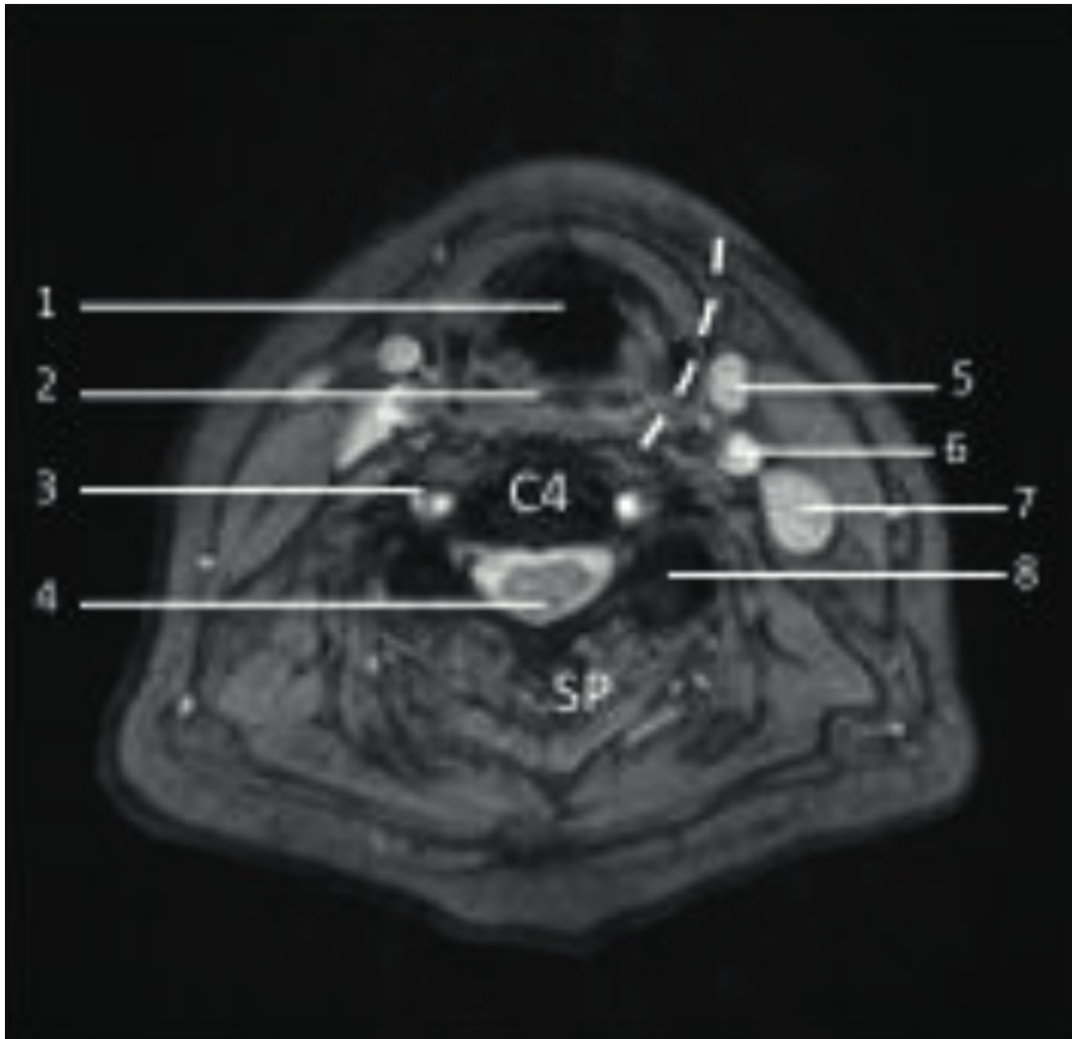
Magnetic resonance imaging axial cut at C4 demonstrating normal anatomy. 1, trachea; 2, esophagus; 3, transverse process (foramina transversaria); 4, spinal cord (note the high-intensity signal surrounding the spinal cord (cerebrospinal fluid)); 5, external carotid artery; 6, internal carotid artery; 7, internal jugular vein; 8, facet joint complex; dotted line, surgical plane for ACDF.
